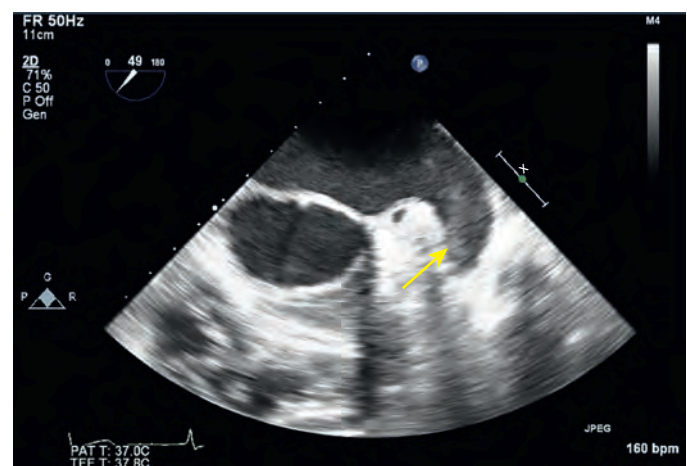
Spontaneous echocardiographic contrast. Because of the low flow in the left atrium, there is low-velocity blood flow with subsequent rouleaux formation by red blood cells (yellow arrow). (Video available online.)
